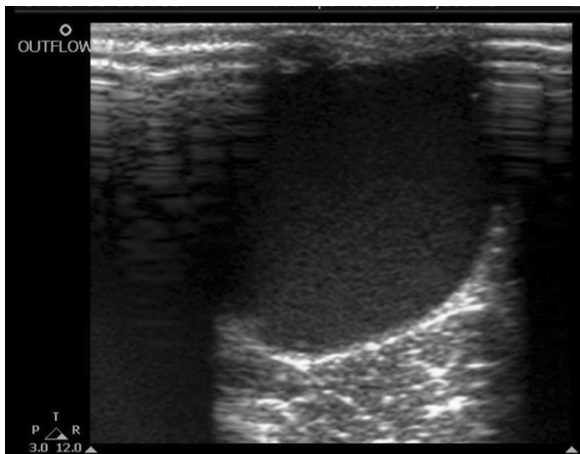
Sonographic examination at site of the AVF showed pseudoaneurysm
